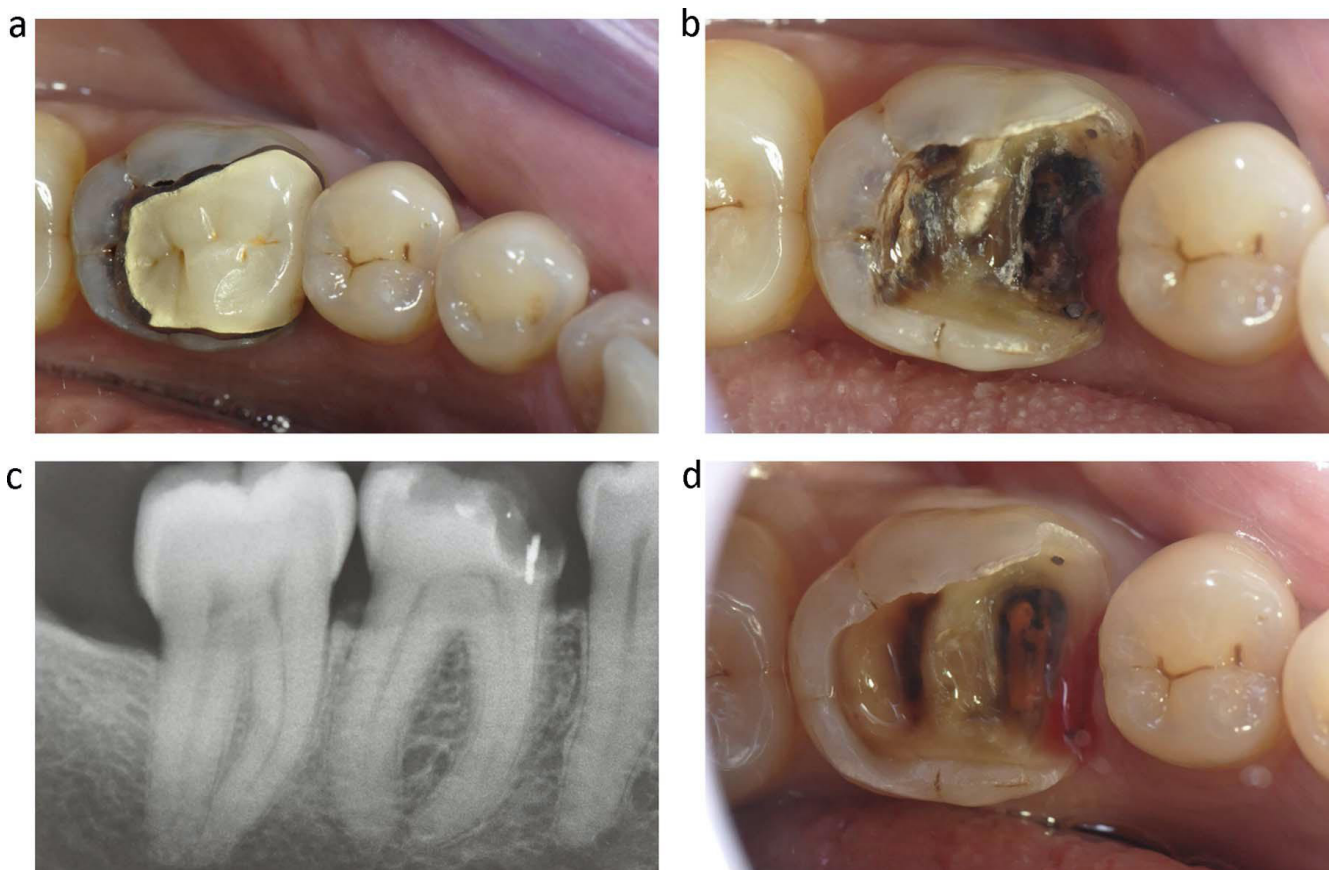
a, b. Old indirect restoration made with porcelain fused to metal in need to be replaced because secondary decay. c. X-ray of the cavity after the old restoration was removed. d. The cavity after decay removal. The application of a metal matrix protected the soft tissue, although after removing the matrix the tissue is slightly bleeding.
